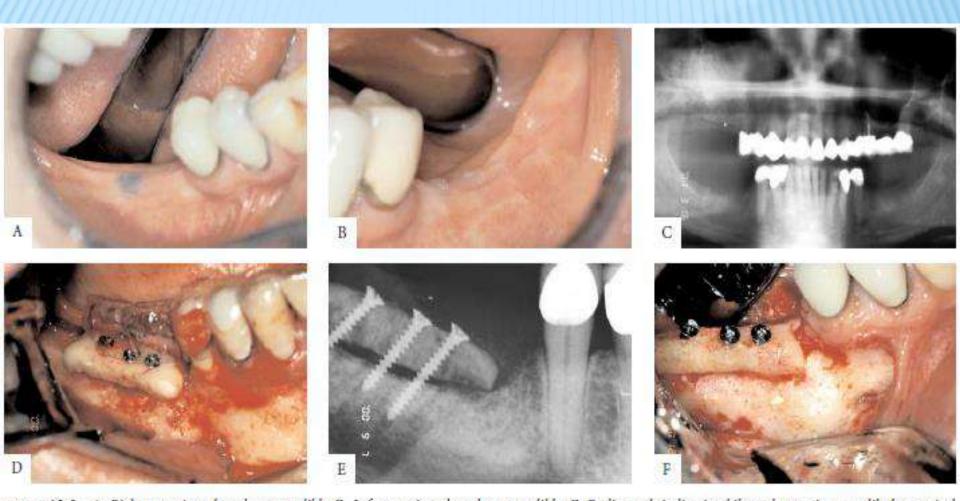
A, Right posterior edentulous mandible. B, Left posterior edentulous mandible. C, Radiograph indicating bilateral posterior mandibular vertical deficiency. D, Block graft fixation with platelet-rich plasma application. E, Block graft fixation. Note butt joint at anterior recipient donor interface. F, Excellent block graft incorporation at 5 months. (CONTINUED ON NEXT PAGE)
